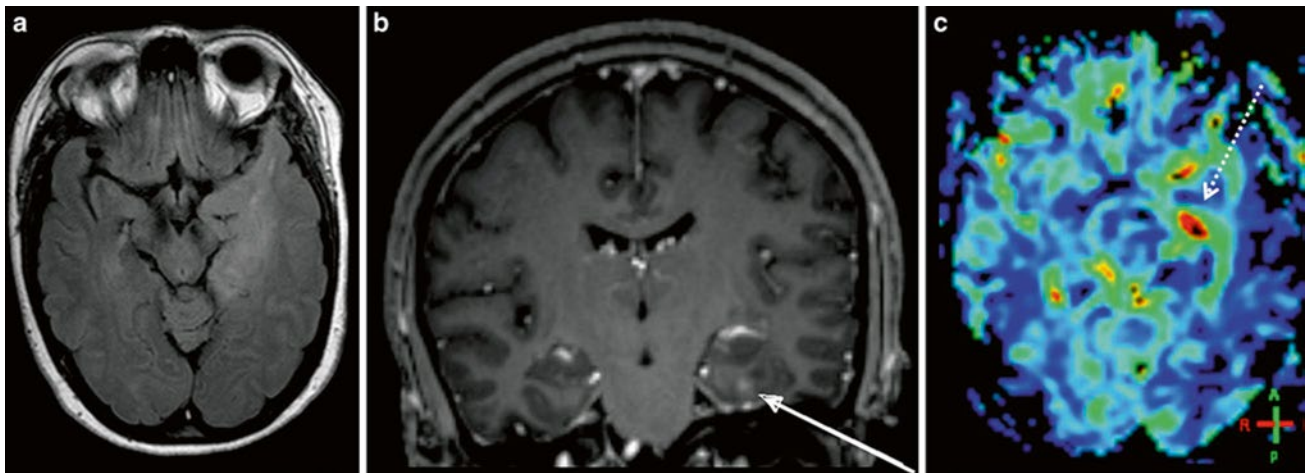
Imaging of a diffusely infiltrating, moderately space-occupying lesion in the left temporal lobe with only a punctual contrast enhancement (arrow): (a) axial FLAIR, (b) coronal post-Gd T1w image, and (c) DSC rCBV map of a selected slice. The lesion is
